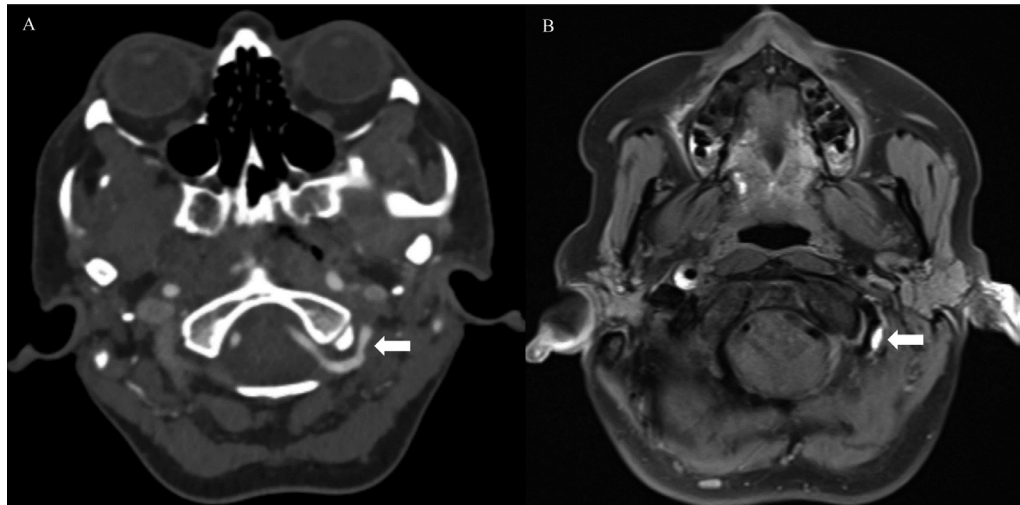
(A) CT angiogram of the neck demonstrates segmental stenosis and concentric mural thickening of the third segment of the left vertebral artery. (B) T1-weighted fat-saturated MRI of the neck demonstrates corresponding intramural T1 hyperintense signal within the third segment of the left vertebral artery, in keeping with intramural hematoma.
